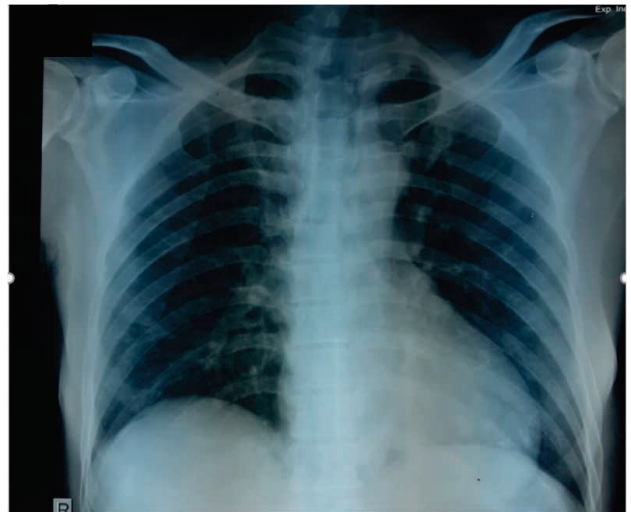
Thorax X-ray normal
